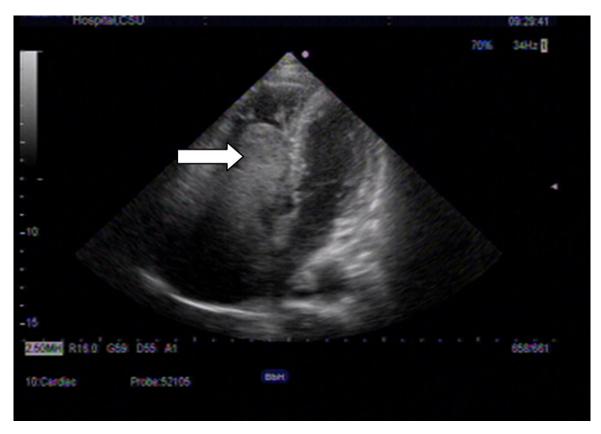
Heart echocardiography showing mass in the right atrium.
